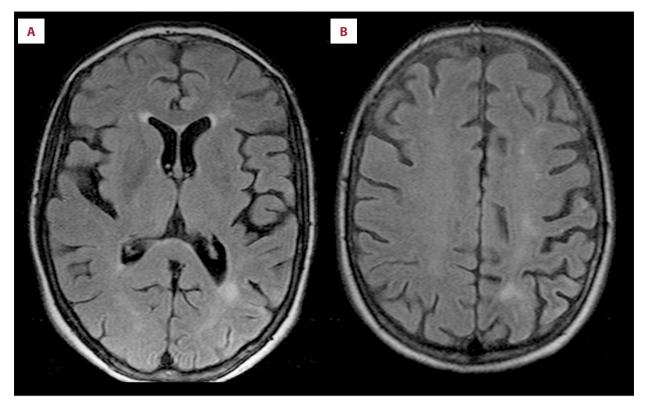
(A, B) Brain MRI. FLAIR (fluid attenuated inversion-recovery). Multiple hyperintense brain lesions.
